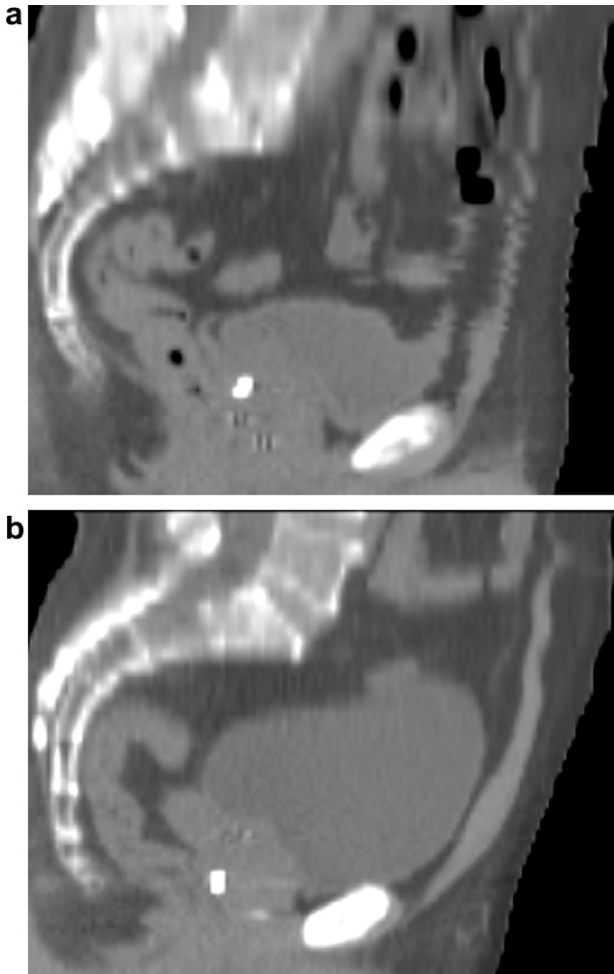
Sagittal planning CT image with patient in VacLok (a) or BodyFix (b) device. Note the differences between the abdominal motion on the position of the anterior abdominal surface and musculature, and the anterior aspect of the bladder.
